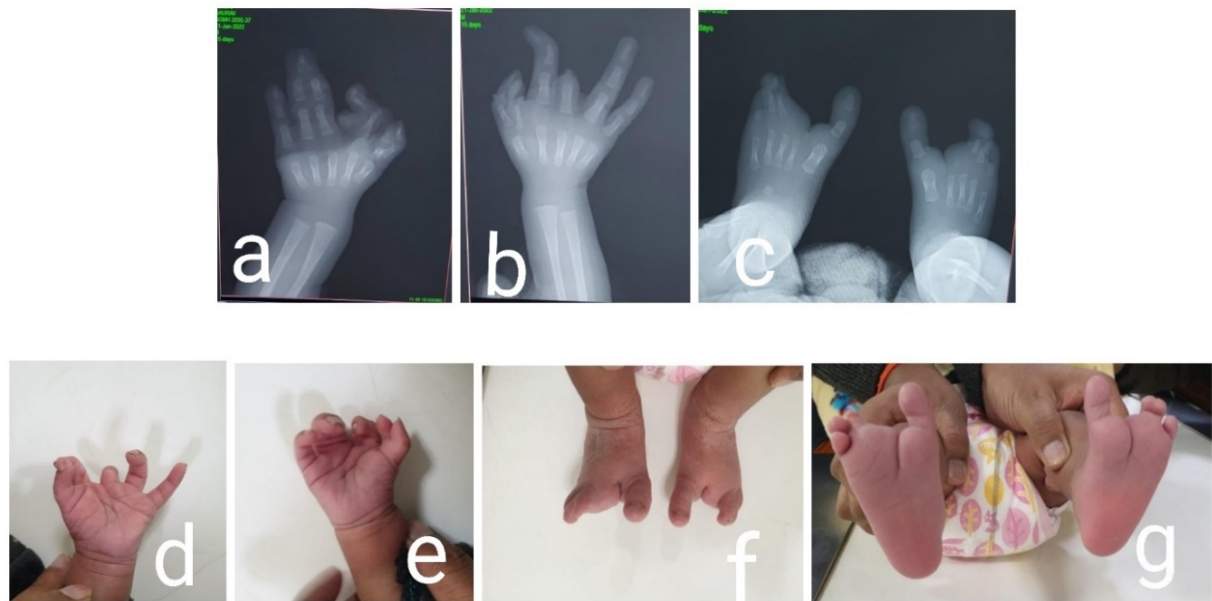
The clinical picture shows Bilateral feet with midline cleft with aplasia of the second toe, and fusion of the third and fourth toes (f, g). The bilateral hand shows midline cleft with syndactyly of third and fourth fingers with extra finger beside thumb on right hand and aplasia of the third finger on the left hand (d, e). Antero-posterior radiographs show all the metacarpals and metatarsals are normally developed with aplasia, syndactyly, and polydactyly seen in the toes and fingers (a, b, and c).
